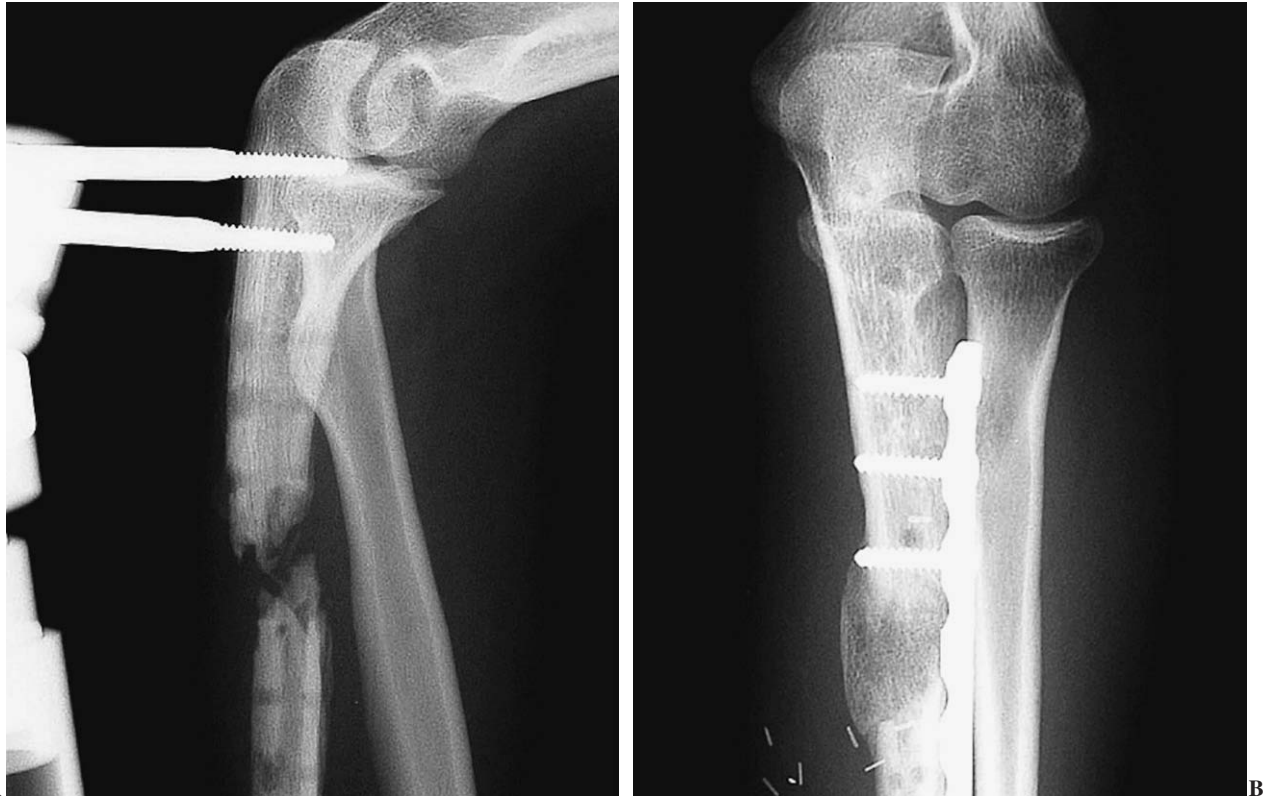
Case 1. Recalcitrant ulnar nonunion. Pre-surgical X-ray (A); post-surgical X-ray (B), 2 months after intervention. The result after applying the microvascular flap was satisfactory.
